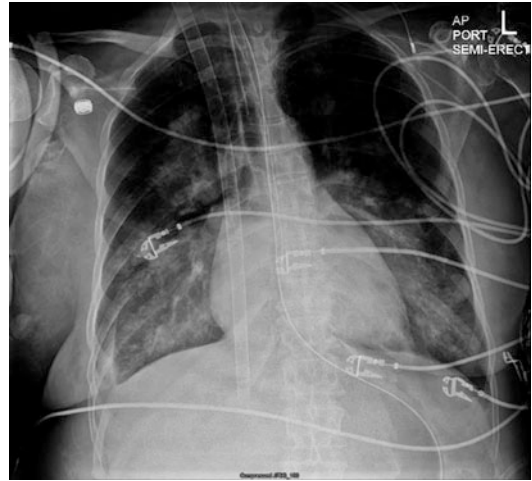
Chest roentgenogram showing the tip of the double lumen cannula in the inferior vena cava. (Courtesy Farzad Najam, MD)
